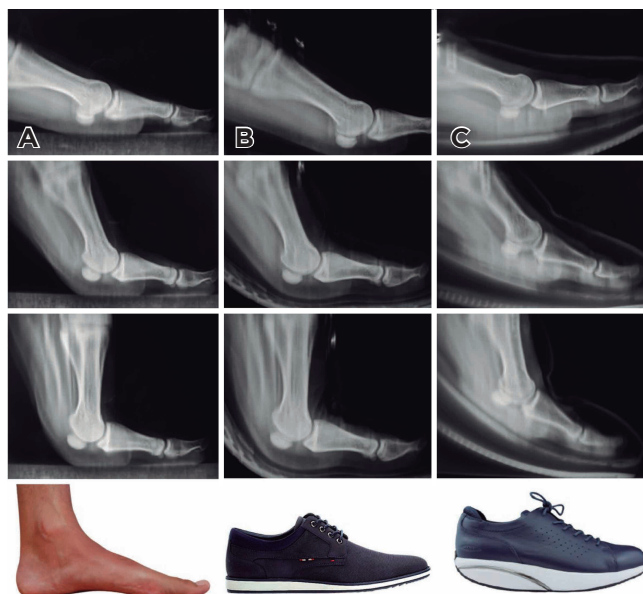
Profile radiography during the third rocker of gait. A) Bare foot. B) Foot with a normal shoe. C) Foot using an MBT® shoe. Remarkable loss of mobility in the metatarsophalangeal joint during the third rocker of gait.
